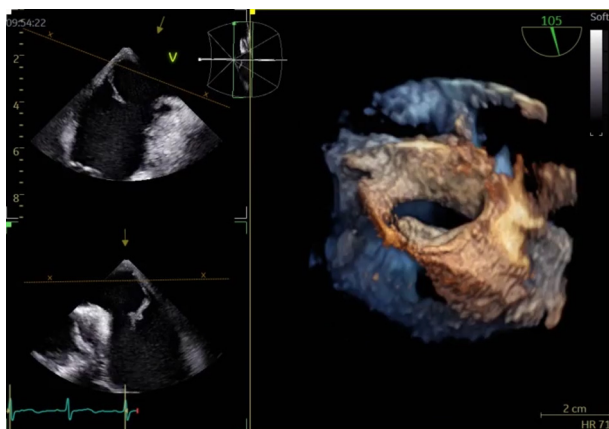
Transesophageal echocardiography revealing an elongated and oval atrial septal defect having no aortic rim. LA, Left atrium; RA, right atrium.
